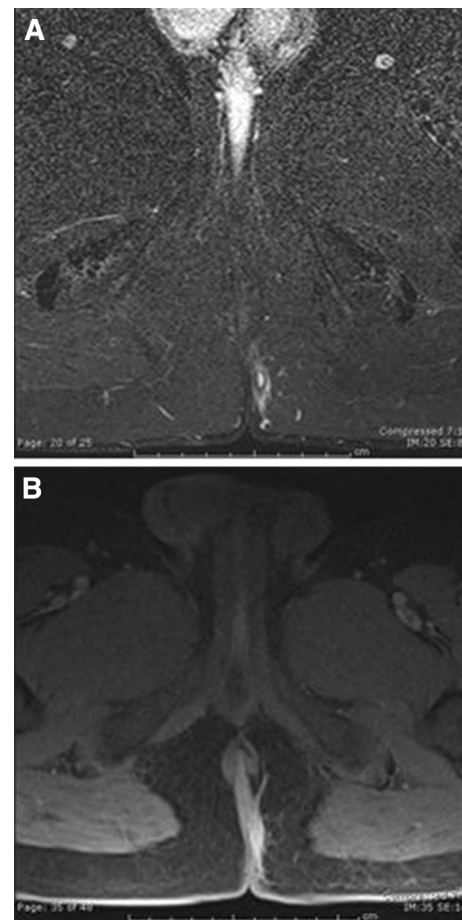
MRI image (STIR T2-weighted and T1 sequences) of a fistula tract after removal of seton and during treatment with anti-TNF- α monoclonal antibody. The tract appears partly fibrotic, but the most caudal portion at the intergluteal sulcus is enhanced, compatible with granulation tissue
